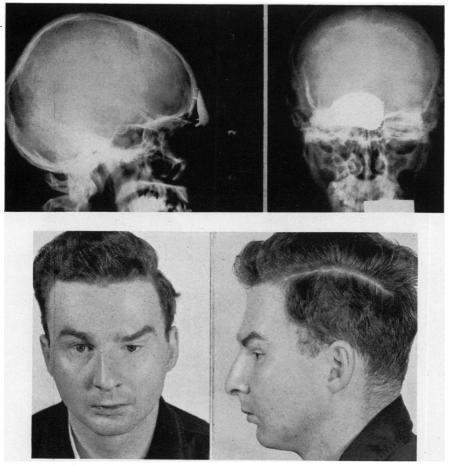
Case 2: Roentgenograms of tantalum cranioplasty and cosmetic restoration after insertion of orbital prosthesis.
